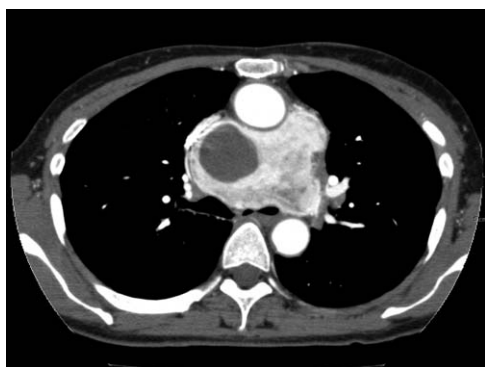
Computed tomography scan showing a large tumor with a cystic region located around the aortic arch and compressing the left main bronchus posteriorly.
